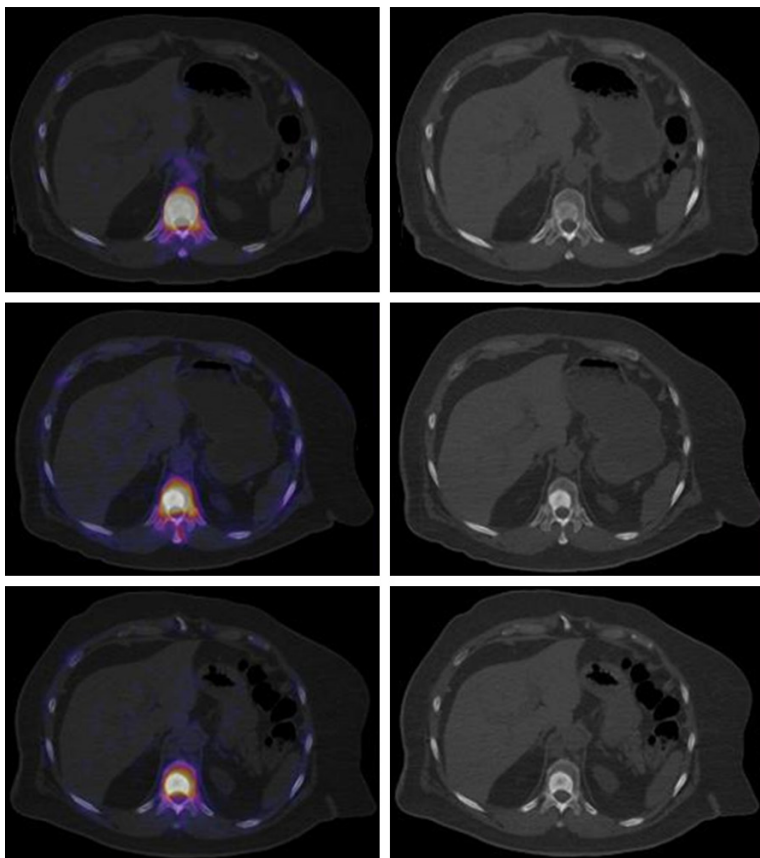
Top. Fused axial slice of baseline ^{18}F -NaF-PET/CT and high radionuclide uptake (left), axial slice showed blastic lesion in vertebral body (right). Middle. Decrease focal uptake in blastic lesion (left), important increase of sclerotic component, after 3 cycles of ^{223}Ra is seen. Lower. decrease focal uptake in blastic lesion (left), note the increase of sclerotic component, after 6 cycles of ^{223}Ra plus ADT.
